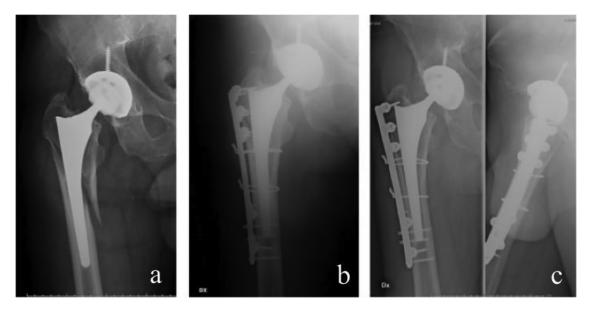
A case of a 71 years old male. Radiographic examination at the moment of trauma (a), post-operative control (b) and after 12 months follow-up (c).
